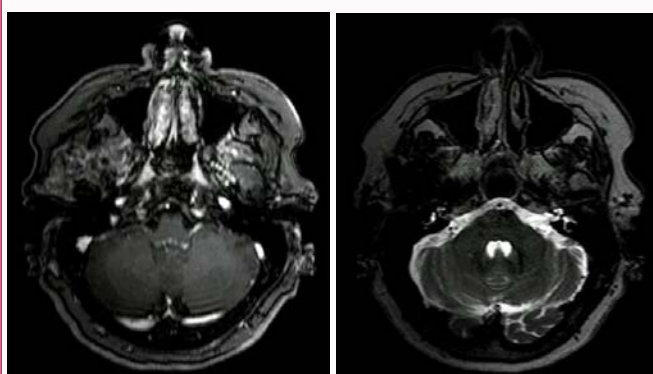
MRI in T1 weighted sequence with gadolinium (a) and T2 (b). The tumor shows heterogeneous enhancement with contrast and is hypointense in T2.
